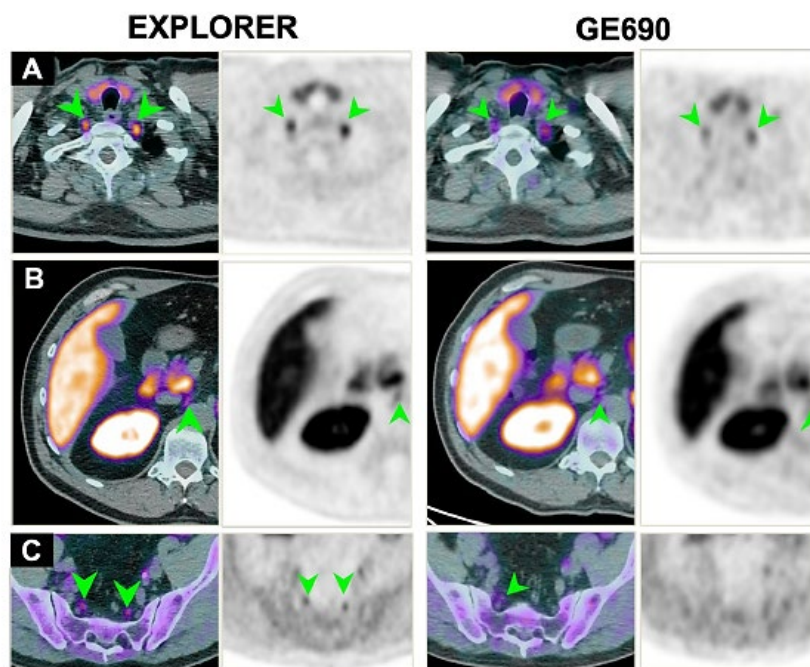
A 59-year-old man with metastatic small bowel neuroendocrine tumor. EXPLORER and GE690 PET/CT images revealed clear visualization of stellate ganglia bilateral (A), while the right celiac ganglia is well-visualized on EXPLORER (B) compared to very faint uptake on conventional scanner (B). The presacral ganglia at S1 are almost only visualized on EXPLORER (C).
